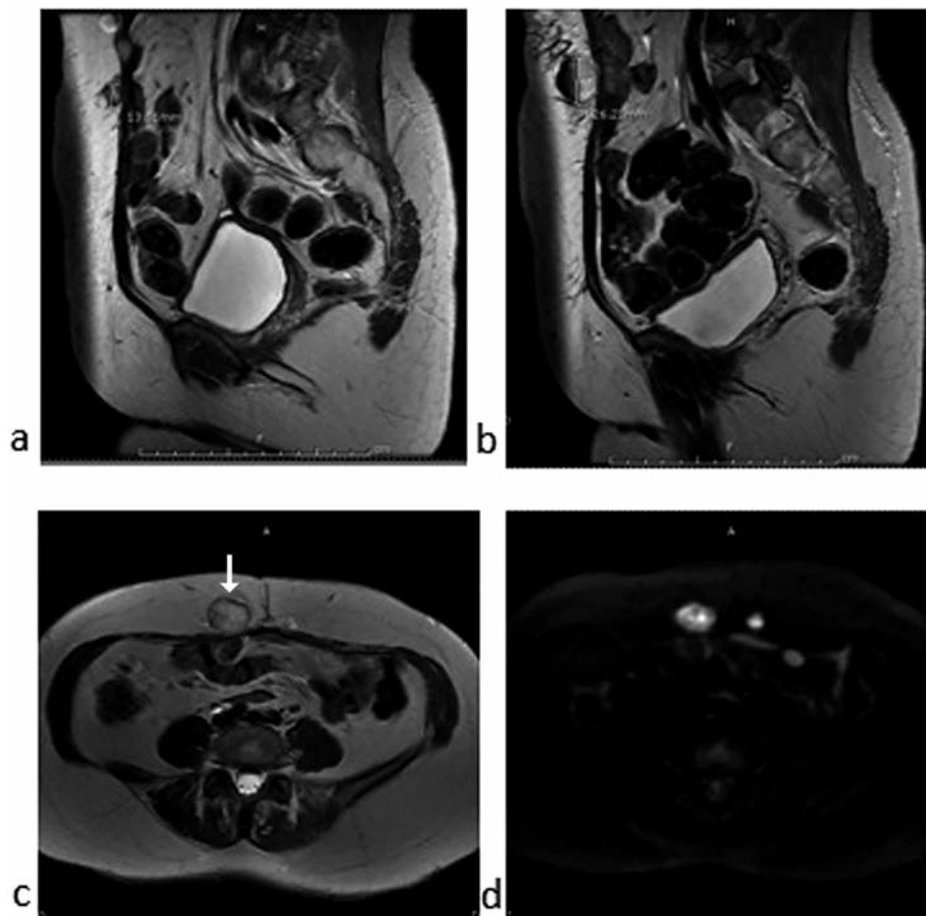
a), b), c) MRI images demonstrating five new subcutaneous nodules in the anterior abdominal wall. The largest nodule is to the right of the midline scar below the umbilicus in the subcutaneous fat, indicated with the arrow. There are four left-sided smaller nodules. d) In diffusion weighted imaging (DWI) all of the nodules demonstrate restricted diffusion and enhancement.
